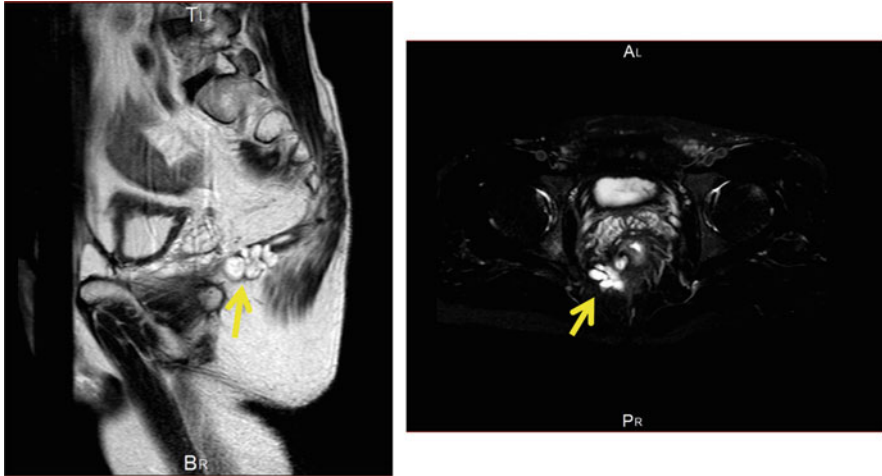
T2-weighted images in patient with mucinous carcinoma. Multilocular cysts indicated by an arrow
